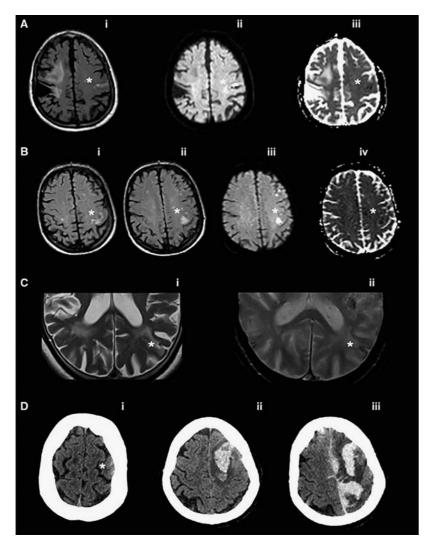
Atraumatic convexal subarachnoid hemorrhage (cSAH)-related ischemia and intracerebral hematomas in different patients. (A) Magnetic resonance imaging (MRI) performed 3 days after the onset of the symptoms showing the cSAH on the left precentral sulcus and a chronic right fronto-parietal ischemic stroke (fluid attenuated inversion recovery sequence) (i). Diffusion-weighted image (DWI) (ii) and apparent diffusion coefficient (iii) sequences show acute ischemia that colocalizes with the cSAH. (B) MRI performed 1 week after the onset of the symptoms showing the cSAH and subacute ischemia on the underlying cortex. Fluid attenuated inversion recovery sequences show cSAH on left precentral sulcus (i) and a hyperintense lesion located on the underlying cortex (ii). This area shows restricted diffusion on DWI (iii) and hypointense signal on apparent diffusion coefficient (iv). (C) MRI demonstrating a pure chronic cortical infarction affecting left posterior parietal cortex. T2-weighted sequence (i) shows the presence of a focal laminar cortical lesion (star). This region colocalizes with an area of cortical superficial siderosis (cSS), as shown in T2*-GRE weighted sequence (ii). (D) cSAH-related intracerebral hemorrhages. (i) Computed tomography (CT) showing an acute cSAH on the superior frontal sulcus. (ii) Three months later, the patient presented a frontal ICH that colocalized with the previous cSAH (iii). Sixteen hours later, the patient's clinical state worsened due to an ICH expansion that led to death after 2 days.
